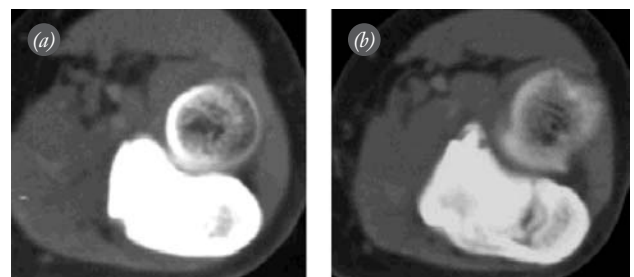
(a, b) CT views at the 6th month follow-up.
